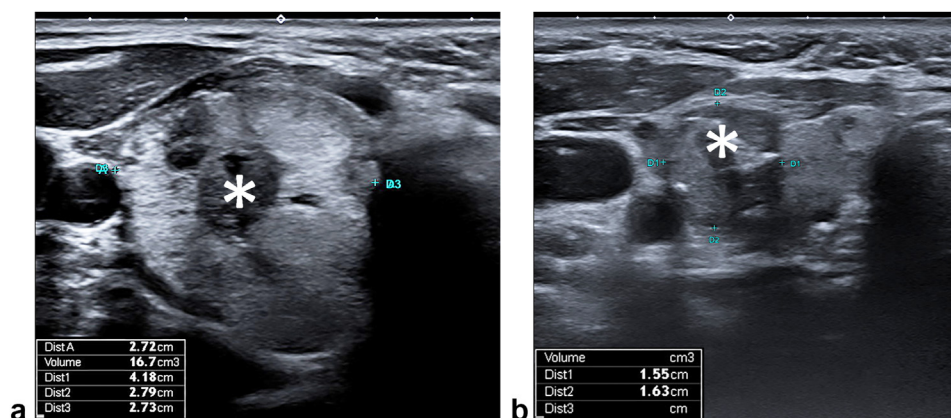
Ultrasound imaging of the thyroid nodules from (a) Patients 2 and (b) 3 at the 3- and 1-month follow-ups after cryoablation showed shrinkage with a volume reduction ratio of 60% and 27.9%, respectively. Central hypoechogenic areas (asterisks) represented regions of cryoablation.
